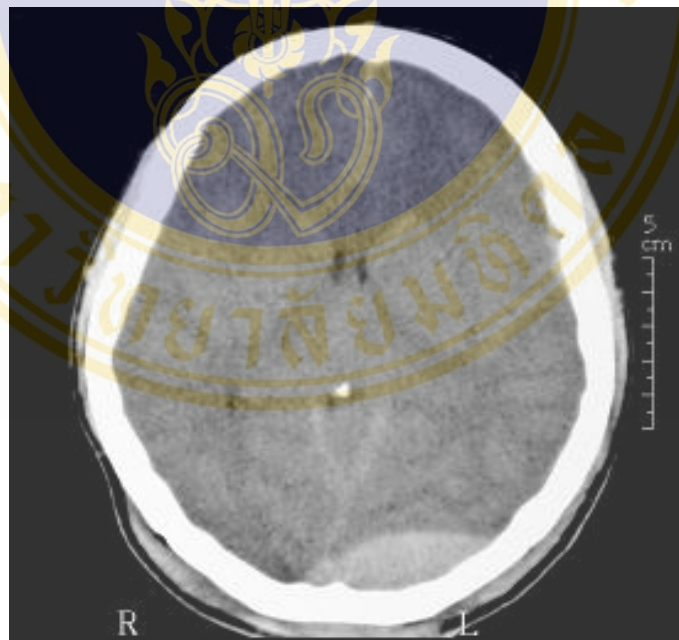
Epidural hematoma in Cranial CT scan is characterized by biconvex shape of hyperdensity and can cross midline (arrows)
